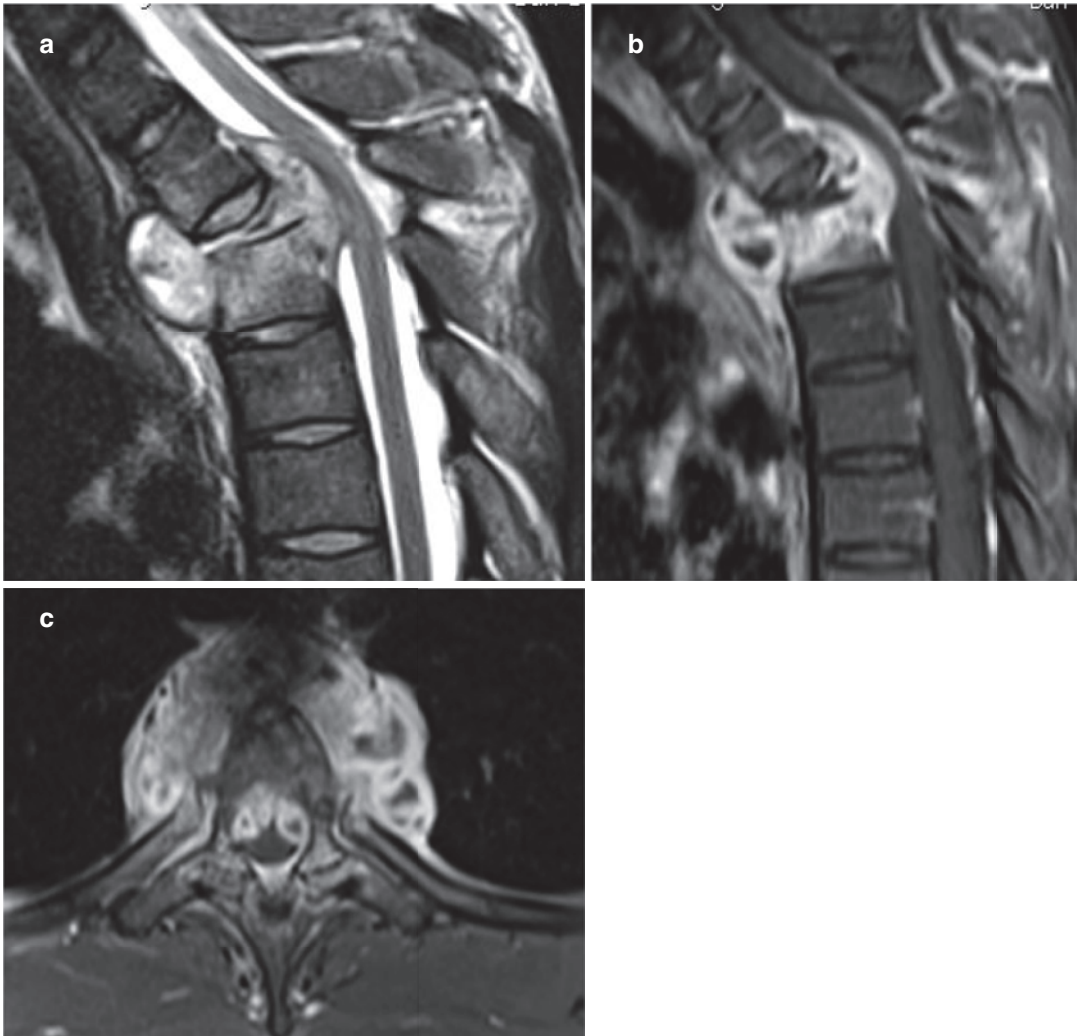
Spinal tuberculosis with cord compression. Sagittal (a) T2-W and (b) contrast-enhanced fat-suppressed T1-W and (c) axial contrast-enhanced fat-suppressed T1-W MR images show disco-vertebral
